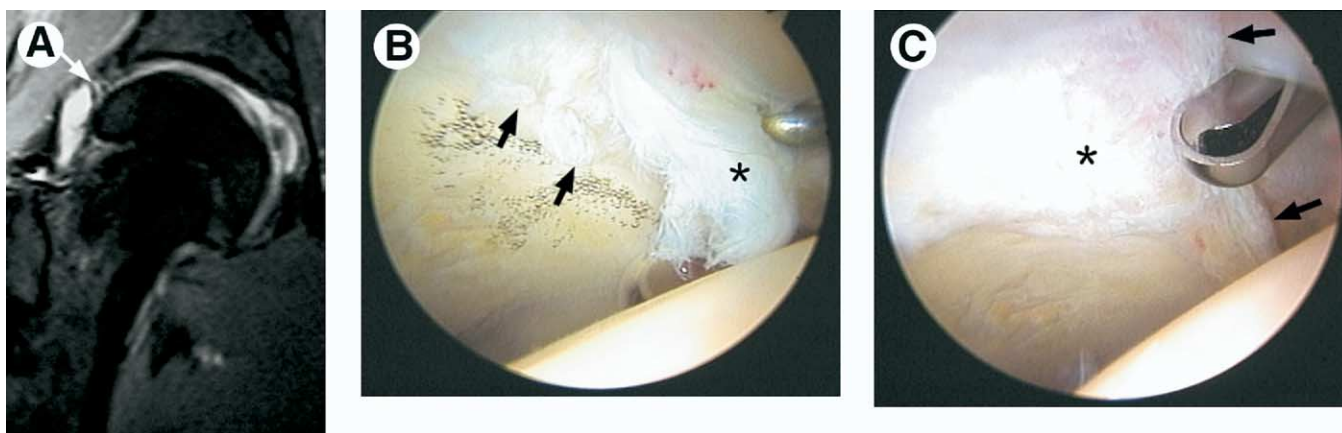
A 25-year-old top-ranked professional tennis player sustained a twisting injury to his right hip. (A) Coronal MRI shows evidence of labral pathology (arrow). (B) Arthroscopy reveals extensive tearing of the anterior labrum (asterisk) as well as an adjoining area of grade III articular fragmentation (arrows). (C) The labral tear has been resected to a stable rim (arrows), and chondroplasty of the grade III articular damage (asterisk) is being performed. (Figure © J.W. Thomas Byrd.) (Color version of figure is available online.)
